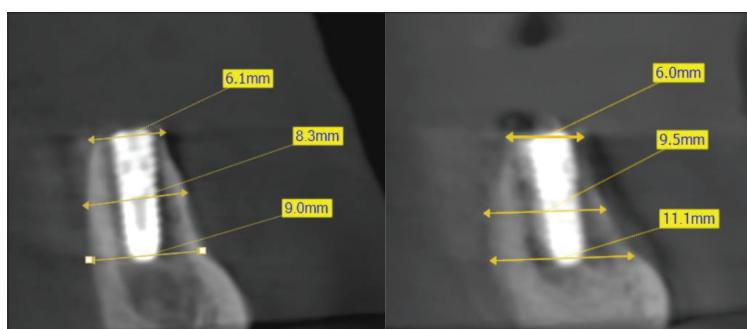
Ideal implant position was confirmed on cross-section CBCT
